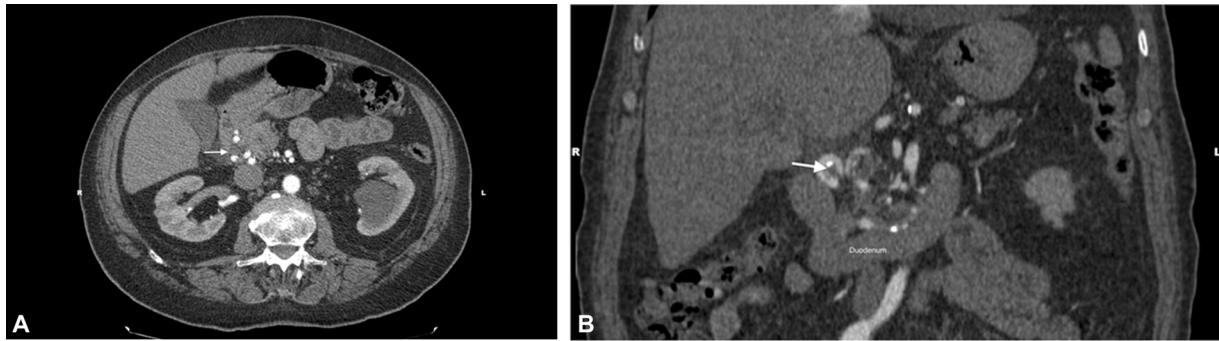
Axial (A) and coronal (B) computed tomographic images showing the arterial compression onto the distal common bile duct (arrows) by tortuous and enlarged inferior pancreaticoduodenal artery branches.
